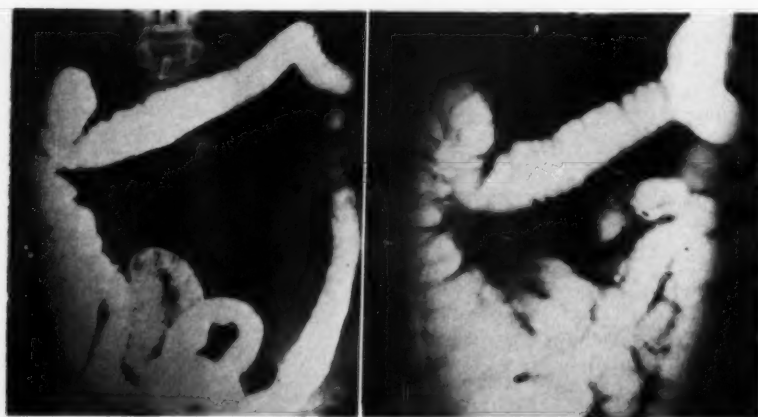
R. K. Reversal of roentgen changes of ulcerative colitis. Extensive disease in 1949; normal colon in 1950.
